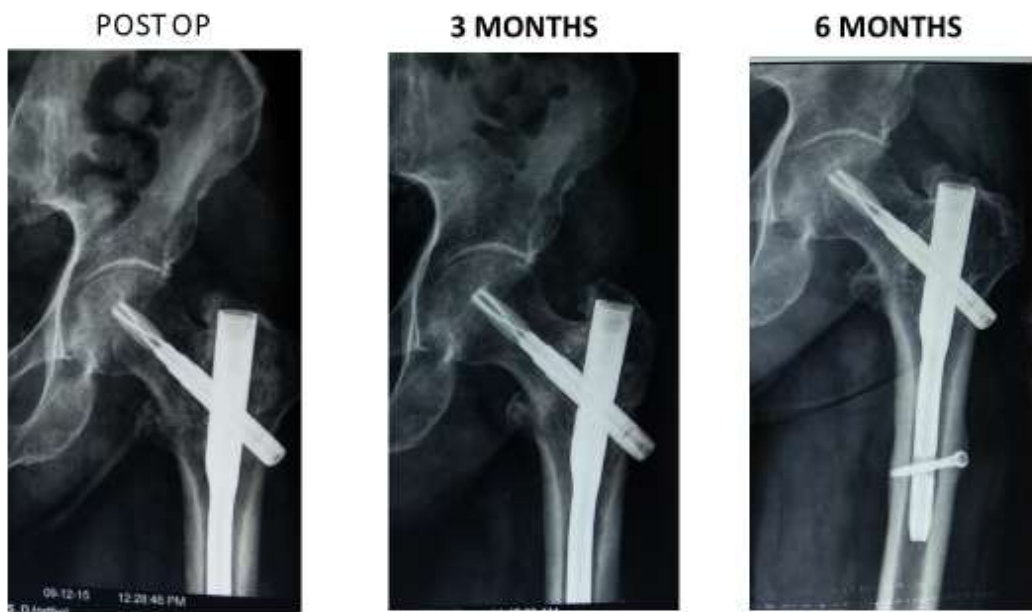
Showing post-op, 3 months and 6 months follow up x-ray
